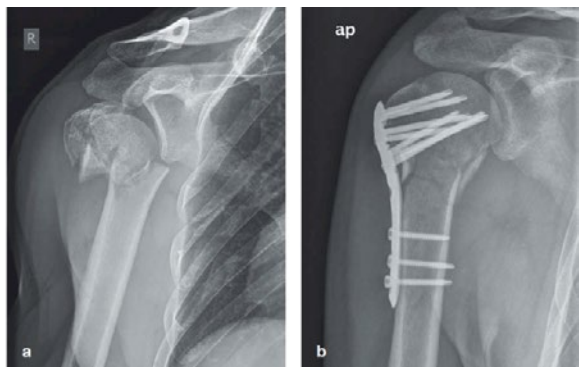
X-Ray of three fragment fracture of the proximal humerus (a) and humerus with implanted bone plate (b)
